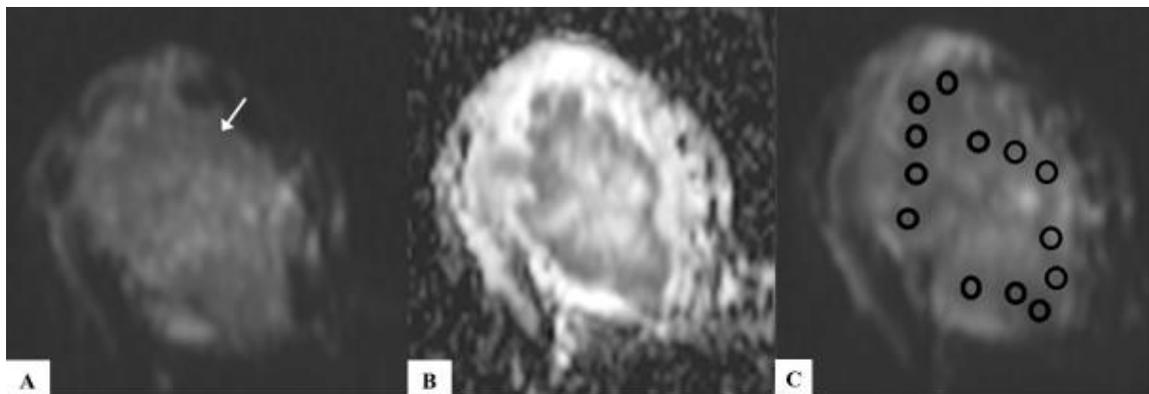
Malignant breast lesion-A) DWI image showing a lesion with irregular margins in right breast (white arrow). B) ADC sequence shows patchy areas of restricted diffusion, predominantly in the periphery of lesion. C) Calculation of mean ADC value- Multiple ovoid ROI each measuring  $\sim 25 \text{ mm}^2$  are placed over the areas of restricted diffusion and ADC value of each ROI is calculated. Mean ADC value of all the ROI is considered as final value. The lesion is diagnosed as infiltrating ductal carcinoma. (ADC – Apparent diffusion coefficient, DWI – Diffusion weighted image, ROI- Region of interest).
